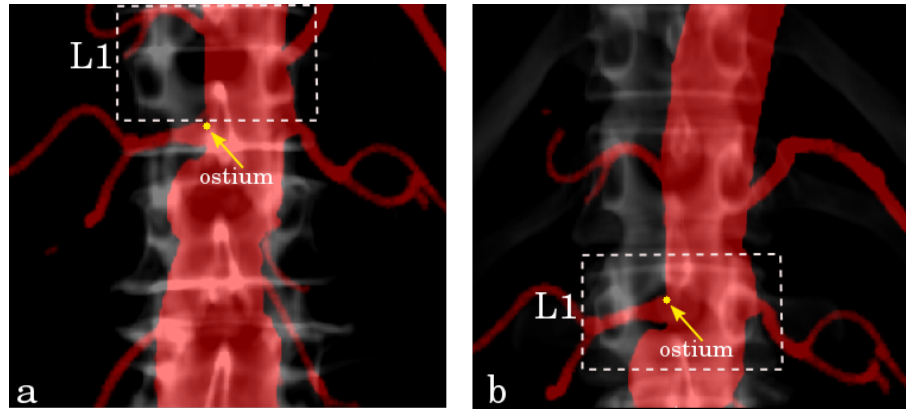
An example of the relative motion of structures at different depths, when X-ray projected from different views. a) $DRR_{vessels}$ was overlaid onto DRR_{bone} in a red colour from an AP view. b) The same DRRs but produced after translating the C-arm -50 mm in the Y direction. In both images, the renal ostium is identified with a yellow dote, while the L1 vertebra is identified with a dashed white box. It is clear that the renal ostium position with respect to L1 has changed (by approximately half the height of the L1 vertebra) as a result of the C-arm translation.
